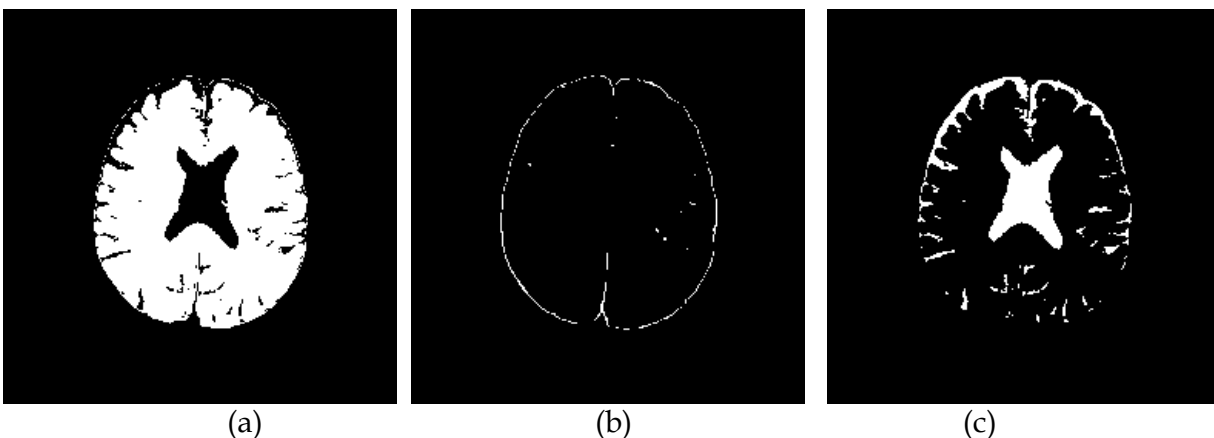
Real Classification result of brain MR images by C-means. (a)GM (b)WM (c)CSF
